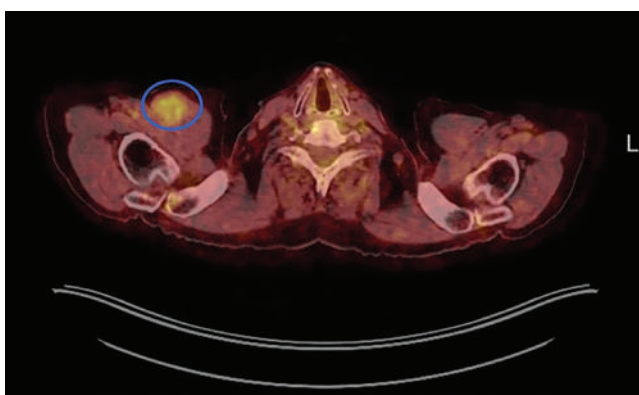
Mass in the pectoral muscle after splenectomy: PET/CT demonstrates uptake within the mass, which is outlined by the blue circle.
